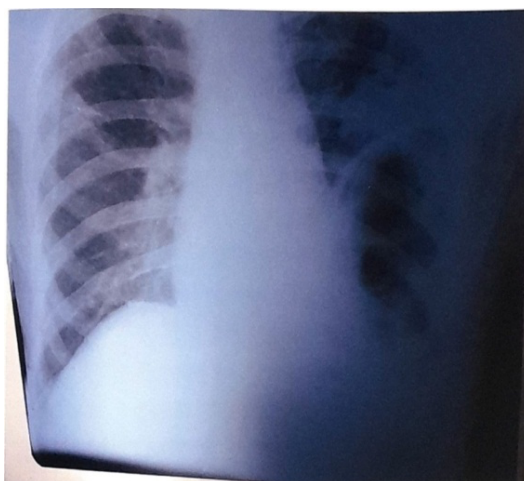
Chest X-ray showing multiloculated pyopneumothorax with pleural fluid smear positivity (CAT II DOTS)
